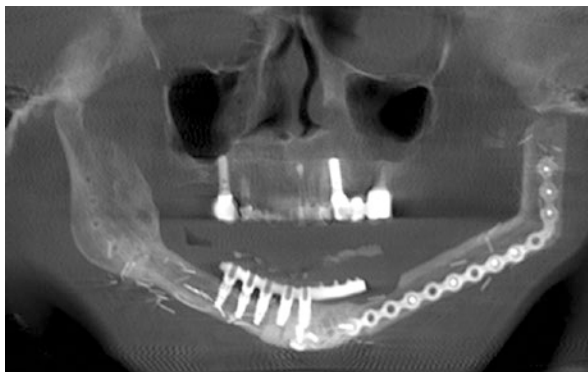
In severe DIONJ cases in patients without multiple myeloma, a free vascular fibula graft followed by dental implant restorations is possible provided radiographs and/or scans rule out metastatic deposits in the fibula
